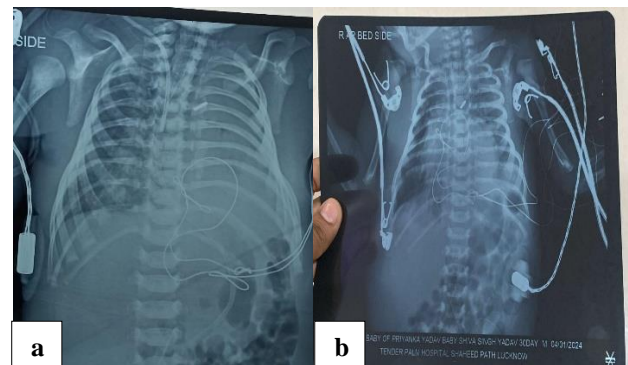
The postoperative chest X-ray (AP view) (a) taken after development of hypoalbuminemia syndrome shows left lung collapse along with pleural effusion, and mediastinum shifted to the right side requiring prolonged invasive and non-invasive (CPAP) mechanical ventilation and vigorous chest physiotherapy; and (b) shows almost normal lung fields without any collapse and pleural effusion, but cardiomegaly still can be observed. the recovery occurred after prolonged mechanical ventilation with IPPV and CPAP ventilation, and chest physiotherapy along with albumin therapy and inotropic support.
